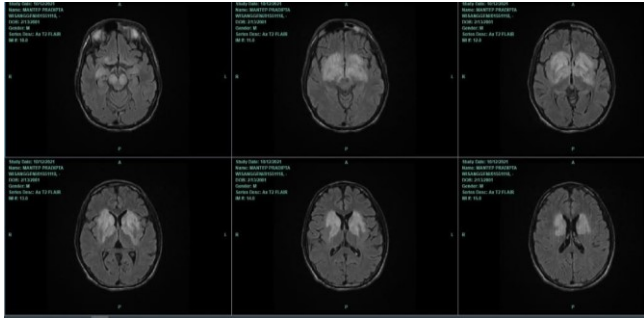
Axial brain contrast MRI on T2-FLAIR sequence
